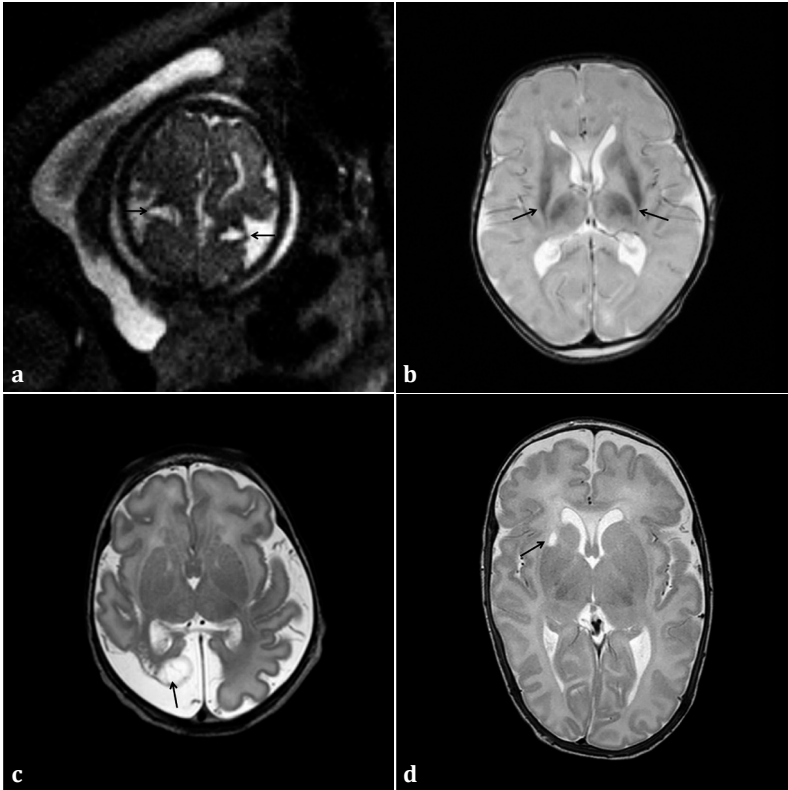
(a) T2-weighted fetal magnetic resonance image (MRI) obtained at 26 weeks' gestation, 3 weeks after single fetal demise in a monochorionic pregnancy, showing bilateral middle cerebral artery infarction (arrows). (b) T2-weighted MRI in a 3-day-old neonate who was born asphyxiated at 36 weeks' gestation, one day after single fetal demise, showing diffuse cortical necrosis, white matter injury and severe basal ganglia/thalamic injury (arrows). (c) T2-weighted postnatal MRI in a 2-day-old neonate who was born at 37 weeks' gestation, 63 days after single fetal demise, showing bilateral severe cerebral atrophy and cystic parenchymal destruction of right posterior cerebral hemisphere (arrow). (d) T2-weighted MRI in a 12-week-old neonate who was born at 28 weeks' gestation, 10 days after single fetal demise, in whom neonatal cranial ultrasound showed Grade II unilateral intraventricular hemorrhage and infarction in the right caudate nucleus (not shown). A cystic lesion in the right caudate nucleus (arrow) can be seen, confirming the ultrasound diagnosis.
